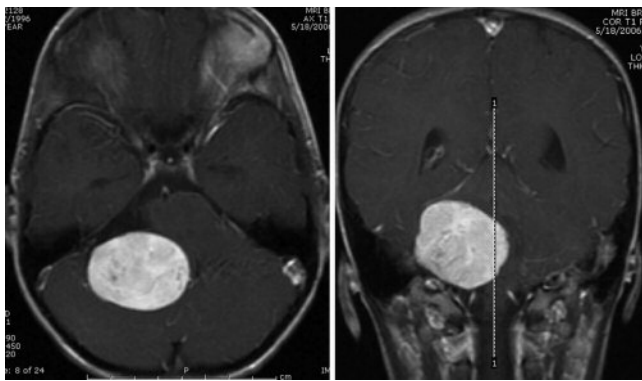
Preoperative axial (*left*) and coronal (*right*) T1-weighted MR images obtained after contrast administration, revealing a large, heterogeneously enhancing mass in the right CPA with significant mass effect on the brainstem and fourth ventricle.
